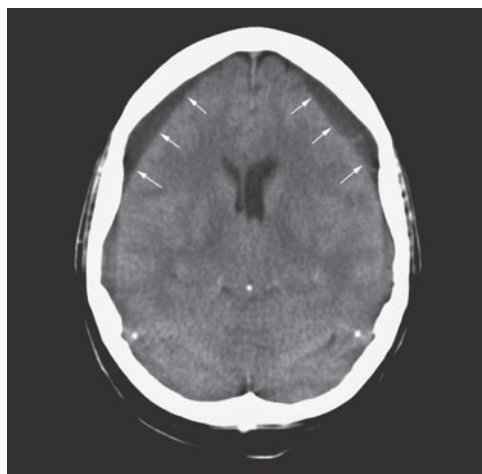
CT scan showing bilateral chronic subdural haemorrhages.
